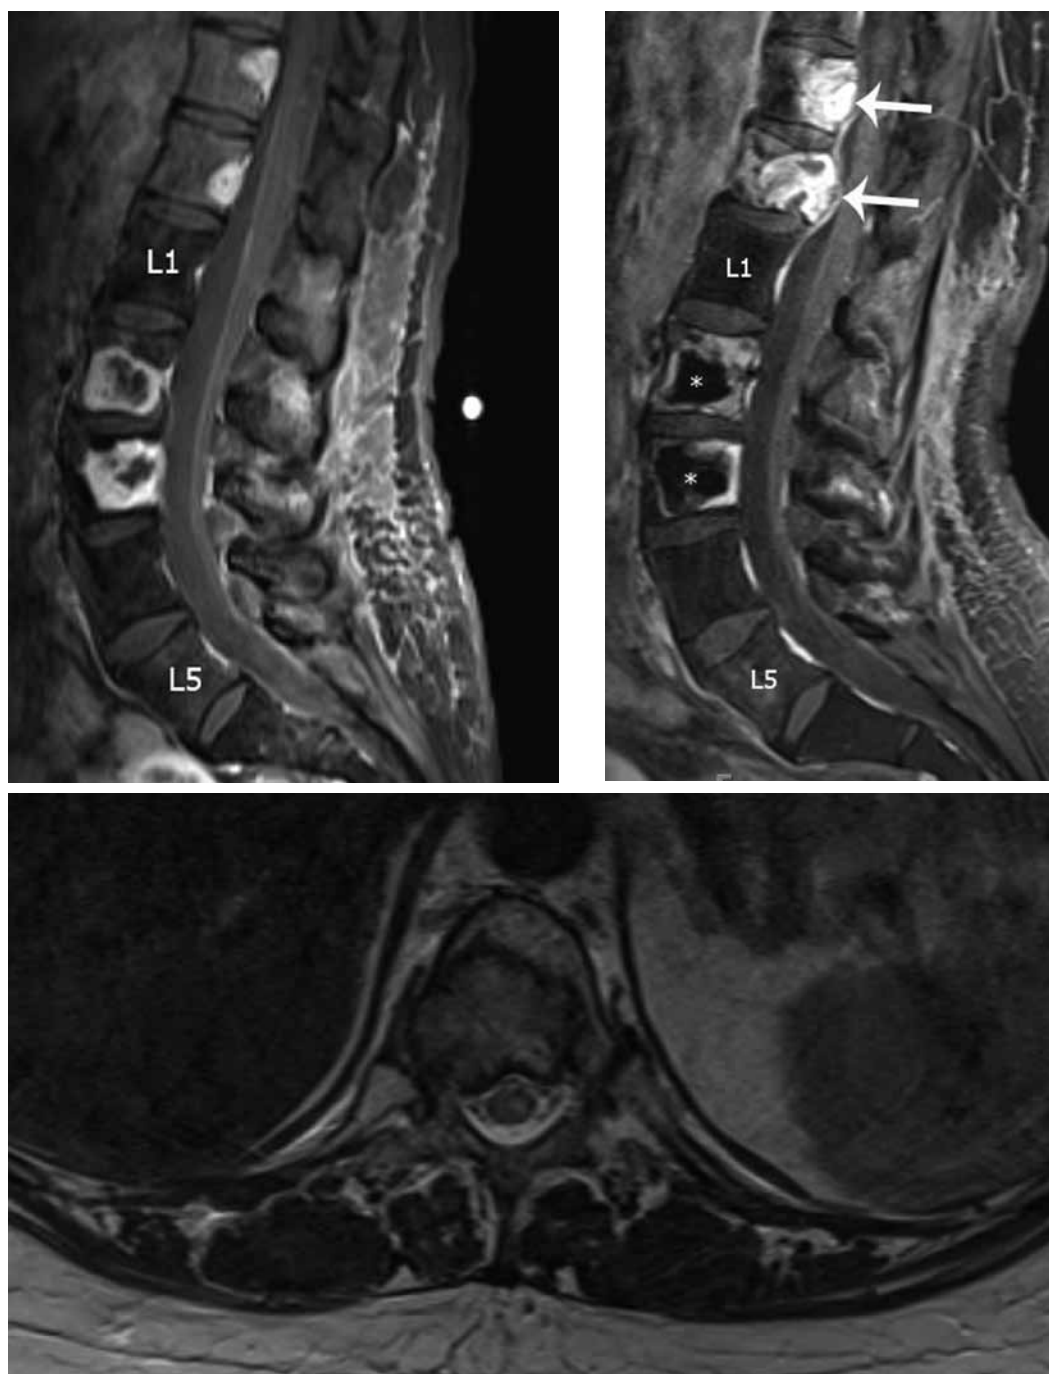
55-year-old woman who has metastatic renal cell cancer with back pain centered at metastatic lesions and pathologic fractures of L2 and L3 treated previously with radiation therapy. Sagittal T1 weighted post contrast MRI image (A) demonstrating large enhancing lesions at L2 and L3 and smaller enhancing lesions at T11 and T12 prior to ablation. L1 and L5 are labeled for counting purposes. Sagittal T1 weighted post contrast MRI image (B) 6 months post L2 and L3 ablation with cement augmentation demonstrating a lack of tumor progression within the treated levels, including posteriorly where no cement was administered (white asterisks), while the adjacent T11 and T12 non-ablated lesions (white arrows) markedly increased in size while on systemic therapy. Axial T2 weighted MRI image (C) demonstrates progression of the T11 tumor into the spinal canal.
